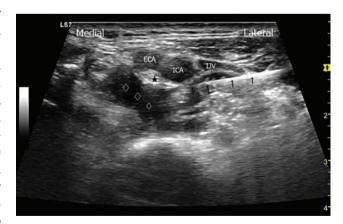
Ultrasound image of spreading local anesthetic (diamond) below superior cervical sympathetic ganglion (asterisk). External carotid artery and internal carotid artery are just starting to branch off the common carotid artery. The black arrows indicate the needle placement. ECA, external carotid artery; ICA, internal carotid artery; IJV, internal jugular vein.
